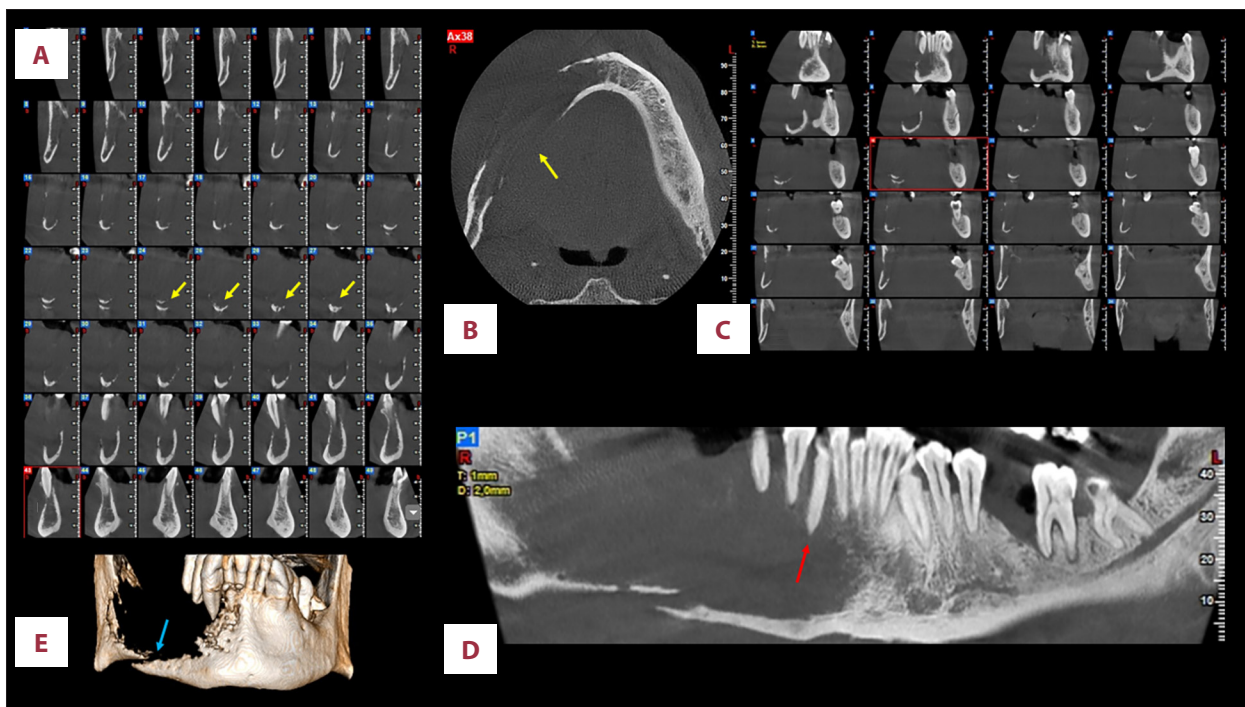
Case 6. (A) Cone-beam computed tomography (CBCT) cross-sectional slices demonstrating complete destruction of the right mandibular body (yellow arrows). (B) CBCT axial slice showing extensive lesion in the right mandibular body (yellow arrow). (C) CBCT coronal slices and (D) panoramic reconstruction highlighting the characteristic floating teeth appearance and spiked-tooth effect (red arrow). (E) CBCT three-dimensional reconstruction revealing a pathological fracture of the inferior border (blue arrow).
